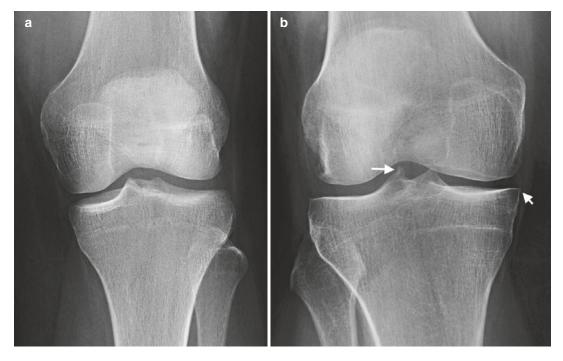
Kellgren and Lawrence radiographic scoring of knee OA. (a) Normal AP radiograph of the left knee, grade 0. (b) Grade 1: doubtful narrowing of joint space and early osteophytic lipping (*arrow*). (c) Grade 2: definite osteophytes, possible narrowing of joint space.
